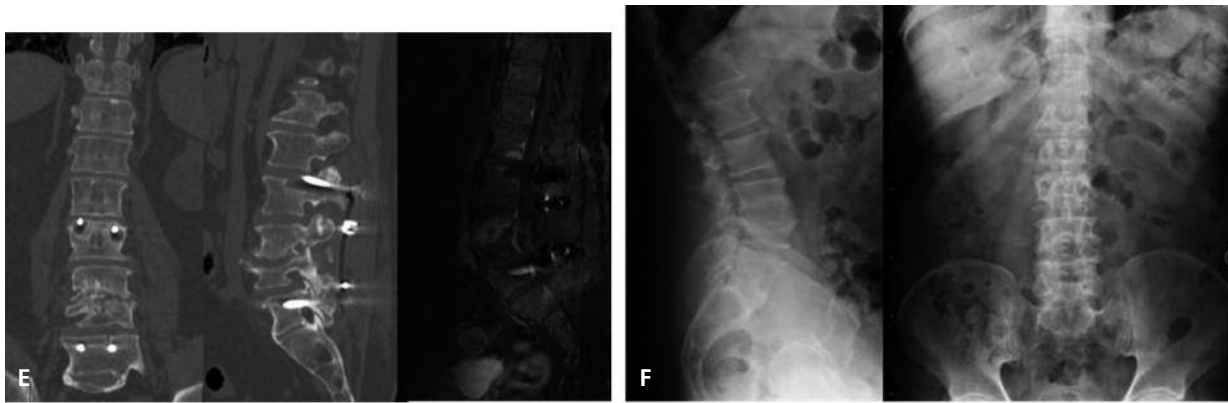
cont'd. CT reconstruction and MR image (E) showed absence of bony fusion, partial dislocation of instrumentation and recurrence of the spinal infection. This was treated by posterior debridement and complete removal of the implanted material. Because of the lack of severe deformity and neurological symptoms, only antibiotic therapy, bed rest and lumbar orthosis were indicated for 3-months after surgery; the 3-months postoperative X-ray image (F) showed initial bony fusion and maintenance of the correct alignment of lumbar spine.
